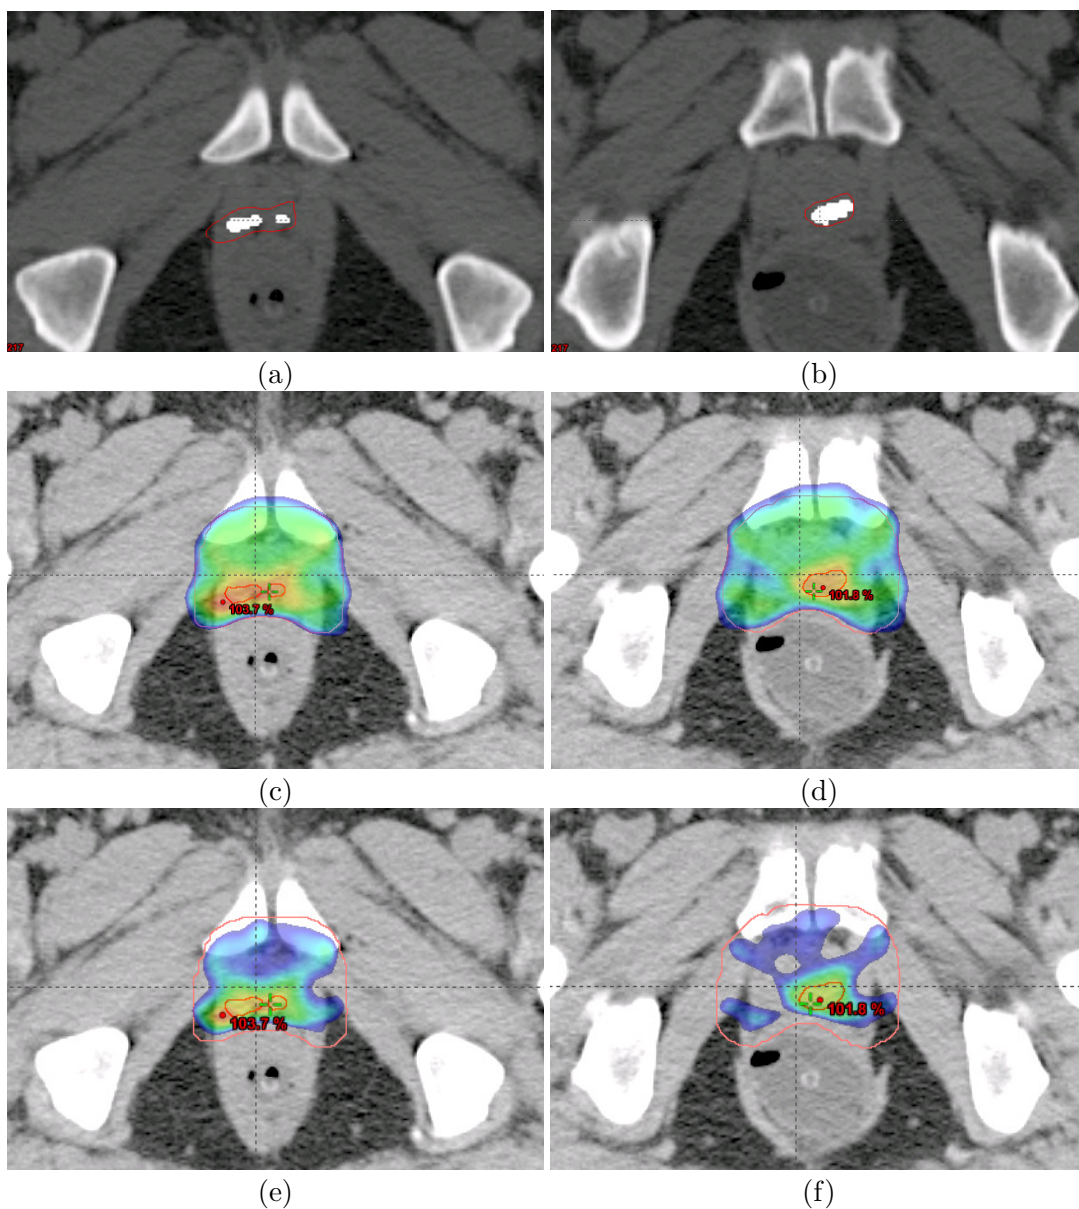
(a), (b) Two different CT studies shown with cancer labels Ω^{CT} (white) mapped from MRI by registration and the resulting cPTV (red line). Resulting dose intensity maps for the slices in (a), (b) are shown thresholded at the minimum dose for PTV (7920 cGy, outer orange line) in (c), (d) and thresholded at the minimum dose for cancer (8640 cGy, inner red line) in (e), (f). These demonstrate dose escalation to the cancer PTV while maintaining dose to the prostate PTV. Note that the original dose plan has not been shown.
